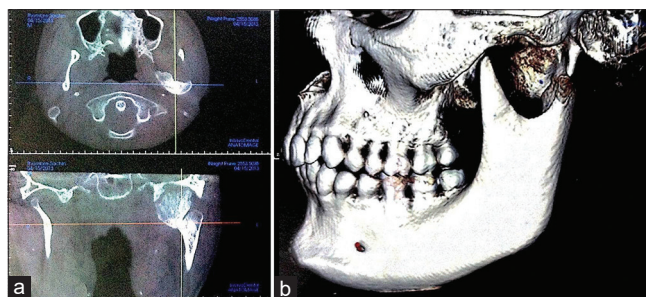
(a) Axial cone-beam computed tomography image showing a solitary irregular bony multilobulated overgrowth over the left condylar head with reduced joint space. (b) Shows cone beam computed tomography reconstructed image
